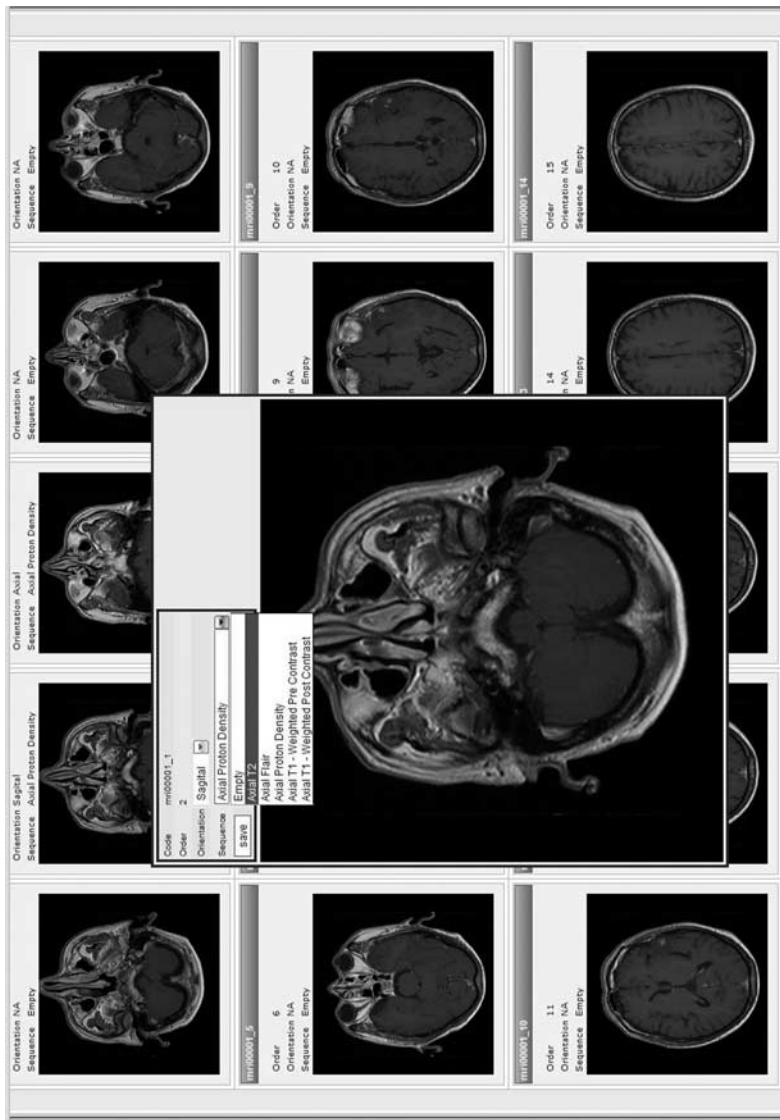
HealthAgents magnetic resonance imaging section
